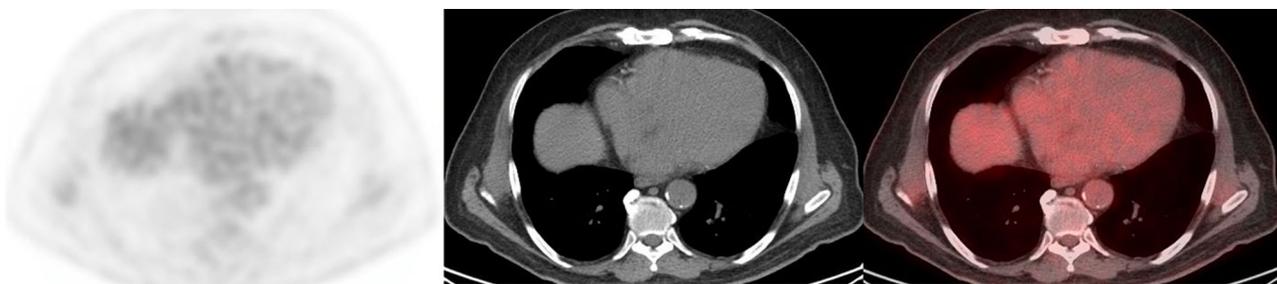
^{18}F -FDG PET/CT viability study showing non-diagnostic images with myocardial FDG uptake similar to blood pool.
